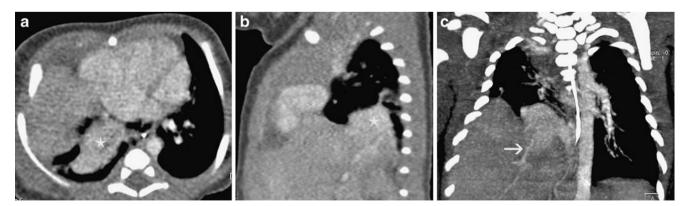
Multidetector CT in the arterial phase following contrast medium injection with axial image (a) and reconstructed sagittal (b) and coronal (c) images demonstrate a slightly heterogeneous contrastenhancing soft tissue mass in the posterobasal right hemithorax
